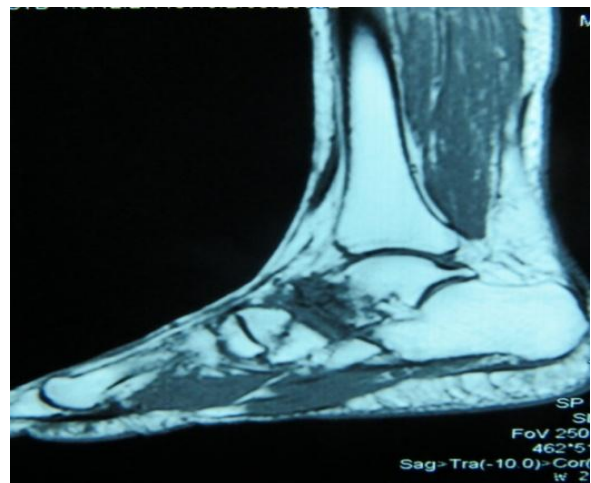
MRI saggittal view delineating the lesion.
